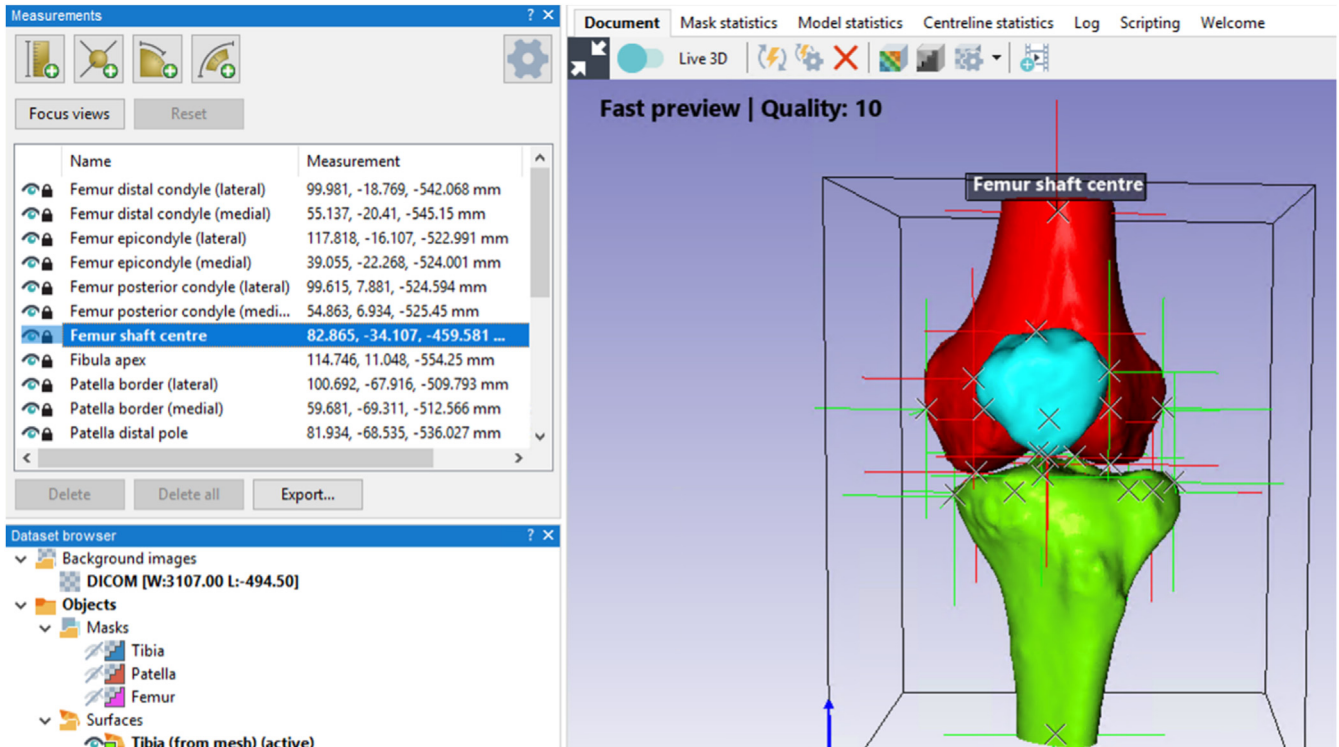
User interface of ScanIP landmark placement. All CT scans of the knee were segmented in Simpleware ScanIP using the CT knee artificial intelligence algorithm. In total, 21 anatomic landmarks were placed on the femur, tibia, and patella. These landmarks were able to be manually dragged around the bone models. (CT, computed tomography.)
